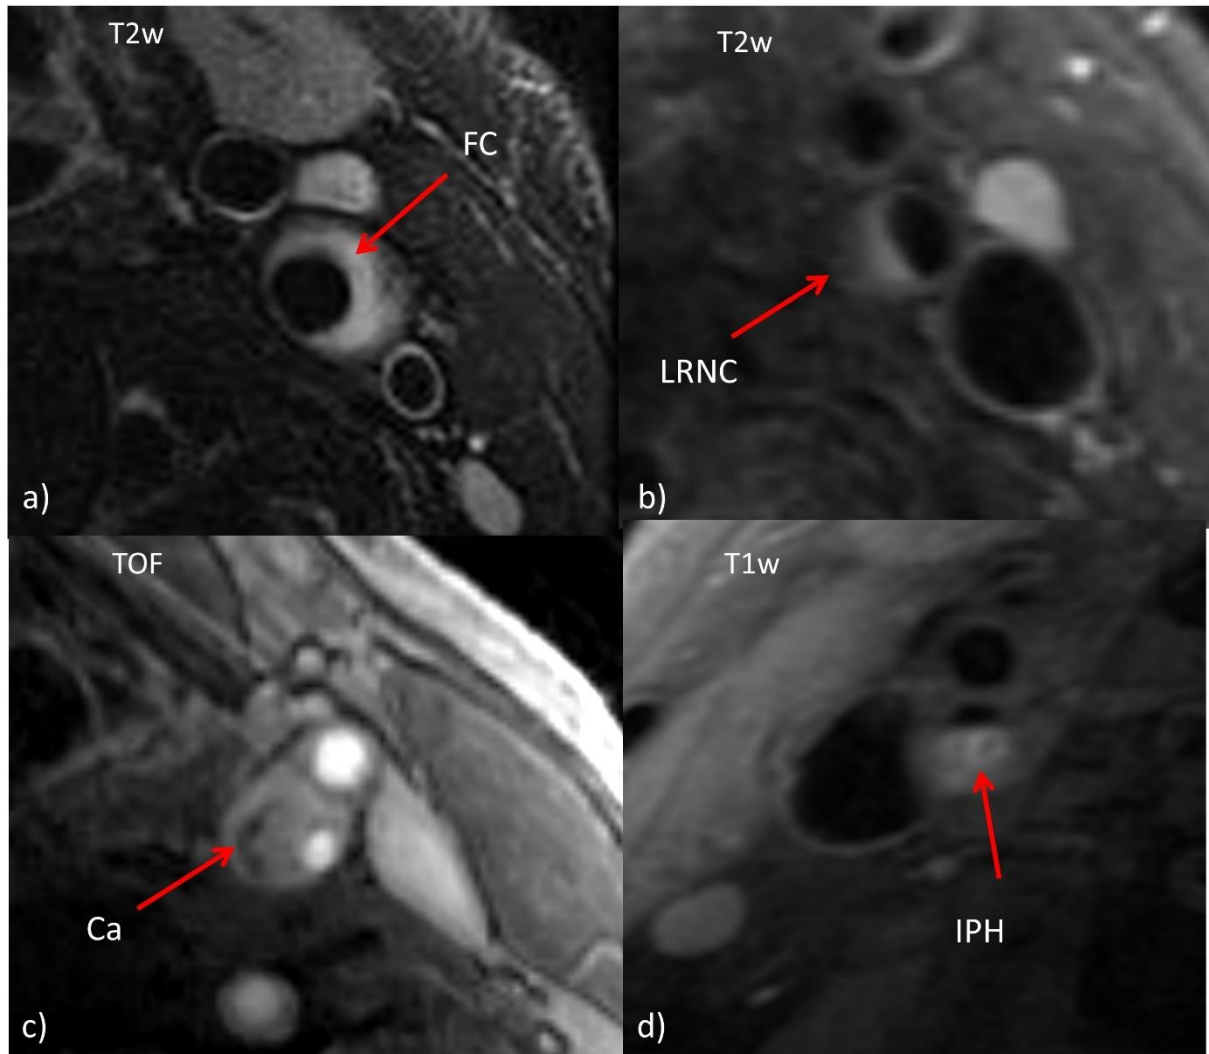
Multi-contrast MRI of carotid plaques can identify features of vulnerable plaques (courtesy of Martin Graves)
